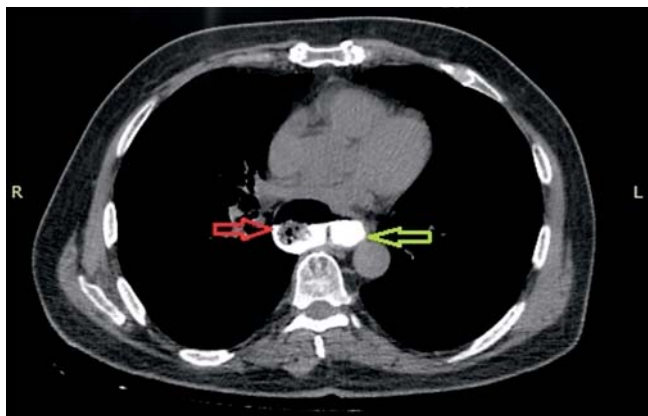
Computed tomography (CT) image of the esophageal diverticulum.
